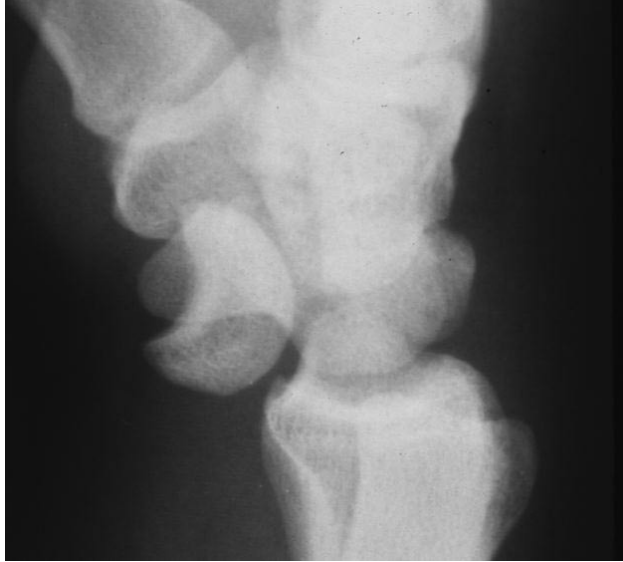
Preoperative lateral radiograph of volar lunate dislocation.
